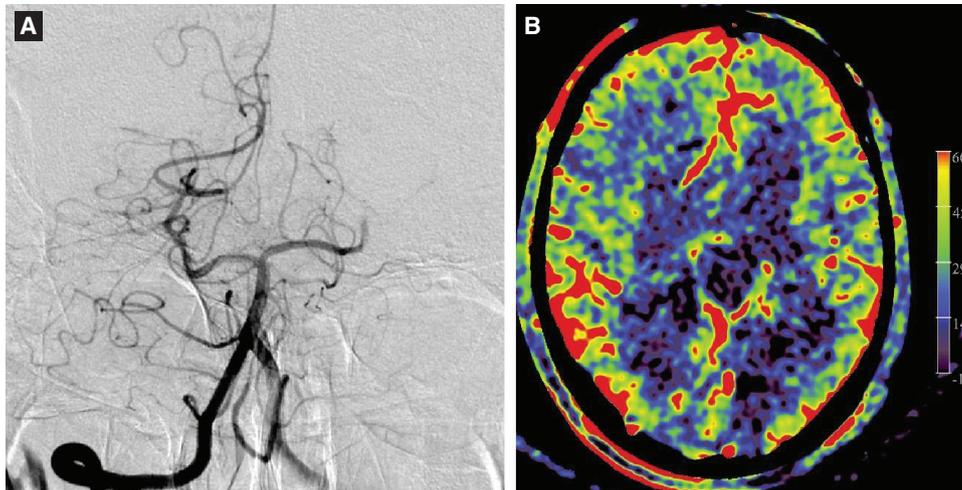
(A) A right vertebral angiogram demonstrating occlusion of the left posterior cerebral artery. (B) An image of flat detector CT perfusion revealing decrease in cerebral blood volume in the left occipital lobe.
